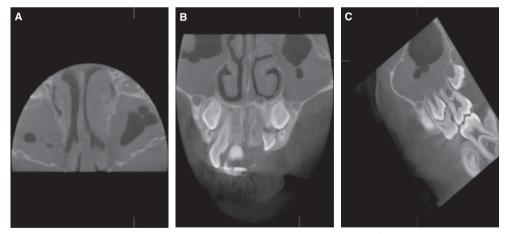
Representative cone-beam computed tomography scans of signs of acute sinusitis in an $8^{1}/_{2}$ -year-old female patient: (A) axial scan; (B) coronal scan; and (C) sagittal scan.
